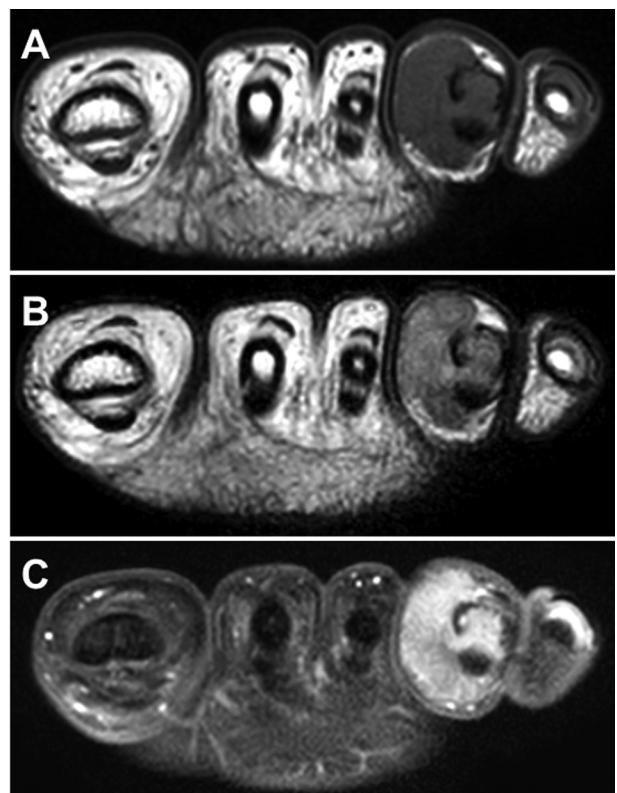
Axial magnetic resonance images of localized tenosynovial giant cell tumor involving the left fourth toe. The mass shows intermediate signal intensity on T1-weighted image (A) and heterogeneous high signal intensity on T2-weighted image (B). Contrast-enhanced fat-suppressed T1-weighted image (C) demonstrates intense enhancement throughout the mass.
